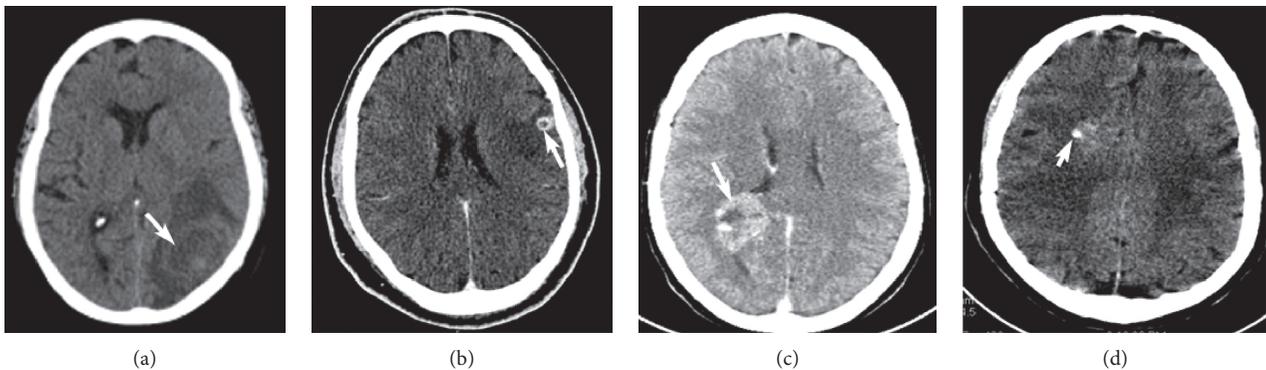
Emergent CT scan of the head obtained in the setting of new-onset recurrent seizures or status epilepticus showing various abnormalities. (a) A CT without contrast showing an area of a rounded lesion (arrow) with perilesional edema proven to be cerebral abscess. (b) A postcontrast CT scan showing a small round enhancing lesion (arrow) with perilesional edema later proven to be neurocysticercosis. (c) A postcontrast CT showing a large enhancing heterogeneous mass (arrow) pathologically proven to be glioblastoma cerebrii. (d) A CT scan without contrast showing an area of calcifications (arrow) in arteriovenous malformation in a young man presenting with recurrent seizures.
